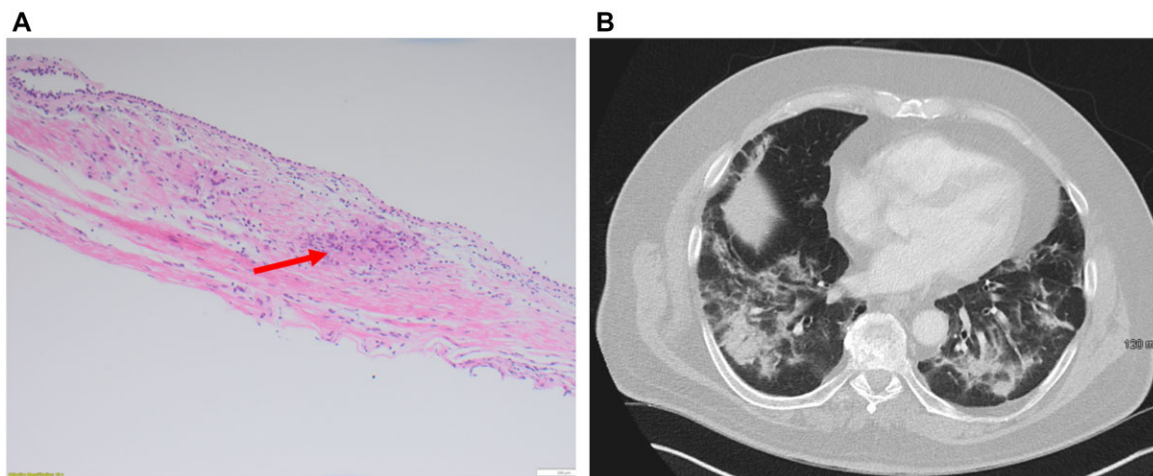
(A) Endobronchial biopsy of the left lower lobe of a patient with PACS 5 months after acute COVID-19 infection demonstrating a non-necrotizing granuloma (red arrow). (B) CT chest. There is extensive bilateral subpleural peripherally located dense consolidation throughout both lungs seen 5 months after acute COVID-19 infection.
